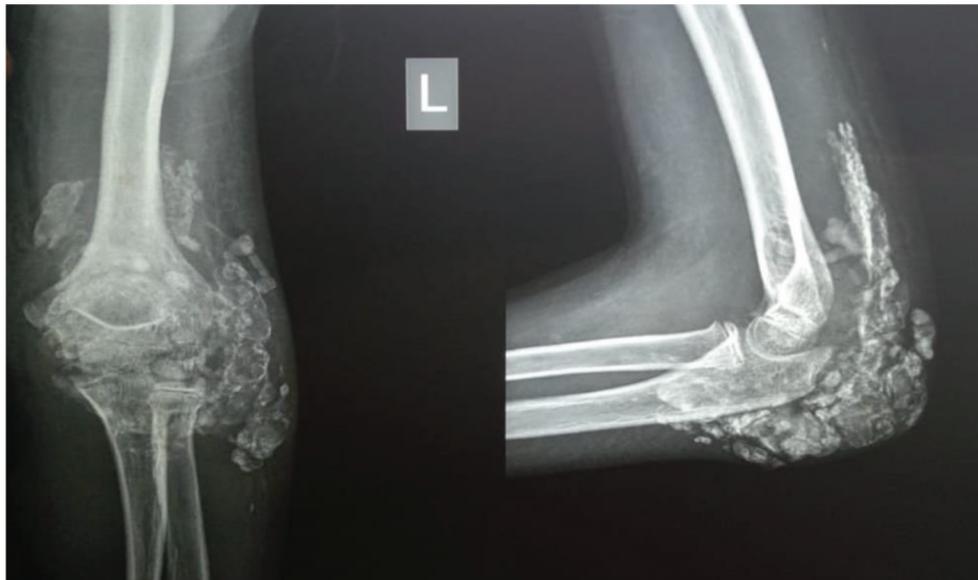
Preoperative radiograph of left elbow showing calcified mass over posterolateral region.
